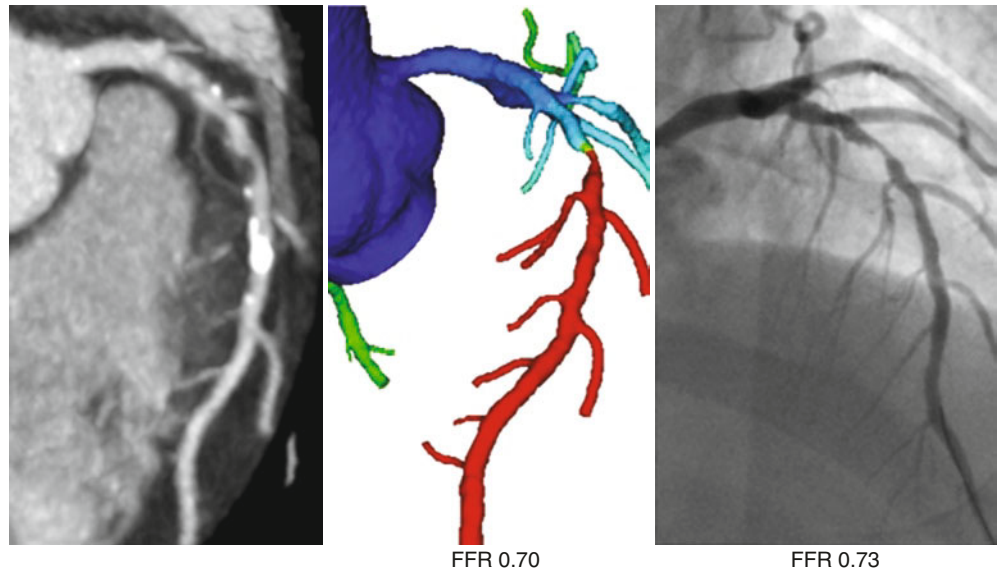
Owing to imaging characteristics, the degree of stenosis from calcified plaque is potentially overestimated, and obstructive disease can be challenging to exclude.  $FFR_{CT}$  can help overcome this problem by demonstrating lack of ischemia in such plaques. Here, the finding of  $FFR_{CT}$  correlates well with invasive FFR
